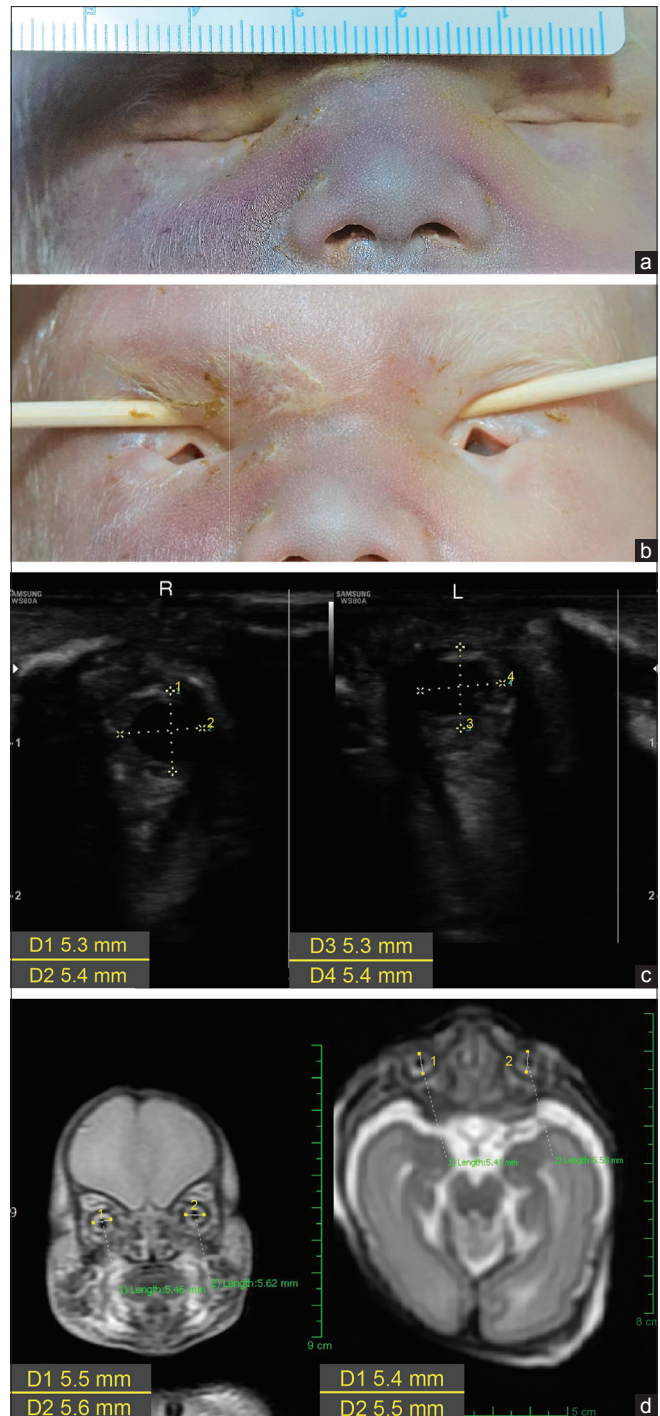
Ocular images of the second induced fetus. (a) The palpebral fissure length (9.0 mm) is significantly short, the inner canthal distance (23.0 mm) is long, and the outer canthal distance (46.0 mm) is normal. (b) Shallow eye sockets with small eyeballs. (c) US showing smaller eyeballs (D1, D2, D3, and D4). (d) Magnetic resonance images confirm the diagnosis of CM (D1, D2, D3, and D4)
